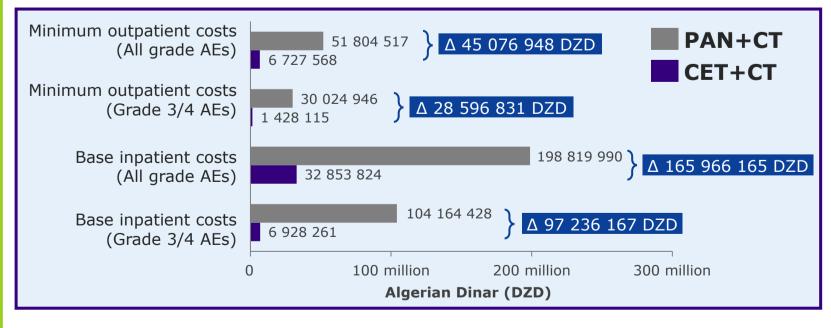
Average per-patient costs of AE management in patients with mCRC receiving CET+CT or PAN+CT
